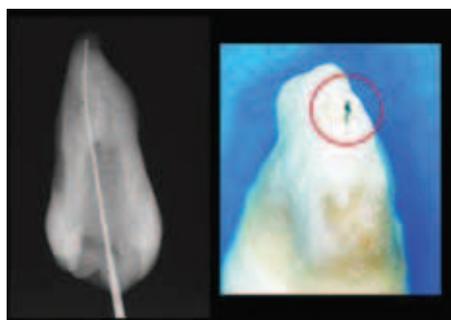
Radiography is an important adjunct to the use of a locator. However, it has been confirmed to be less reliable than an apex locator as the foramen may not end at the radiographic apex.
